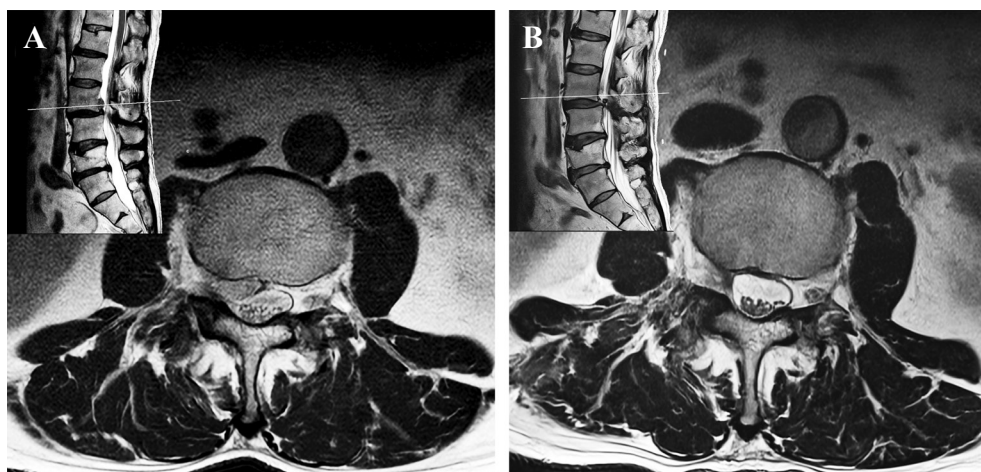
(A) Preoperative axial magnetic resonance imaging (MRI) shows a paracentral up-migration ruptured disc compressing right exiting the L2 nerve root with spondylolisthesis (left upper corner). (B) Postoperative axial MRI shows complete removal of the herniated disc.
